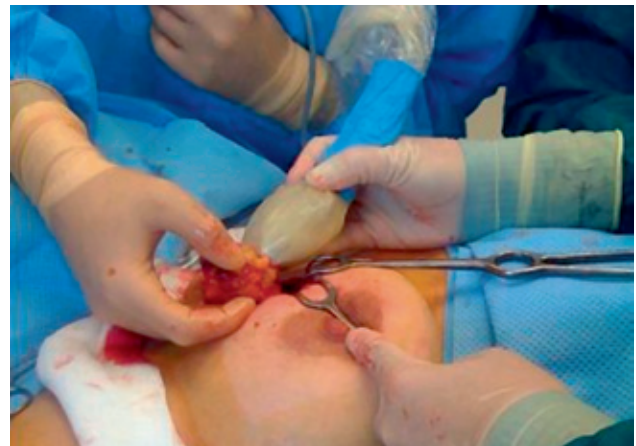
Ultrasound is applied repeatedly in the wound.
